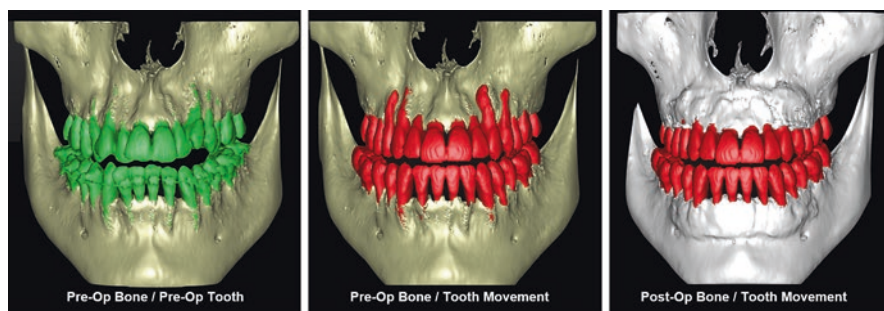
Before and after CBCT imaging and 3D reconstruction. 3D image on the left demonstrates initial regional anatomy phenotype prior to SFOT intervention. 3D image in the center demonstrates projected bone loss patterns if teeth were to be moved without consideration to the dentoalveolar complex. 3D image on the right demonstrates actual outcome post-SFOT treatment (1 year) from CBCT imaging after treatment. Dentoalveolar bone phenotype has been converted from thin crestal, thin radicular to thick crestal, thick radicular dentoalveolar bone phenotype via SFOT. Reprinted with permission from Mandelaris GA, Neiva R, Chambrone L. American Academy of Periodontology Best Evidence Consensus on Cone Beam Computed Tomography and Interdisciplinary Dentofacial Therapy. A Systematic Review Focusing On Risk Assessment of the Dentoalveolar Bone Changes Influenced By Tooth Movement. *J Periodontol* 2017; 88(10): 960–977
